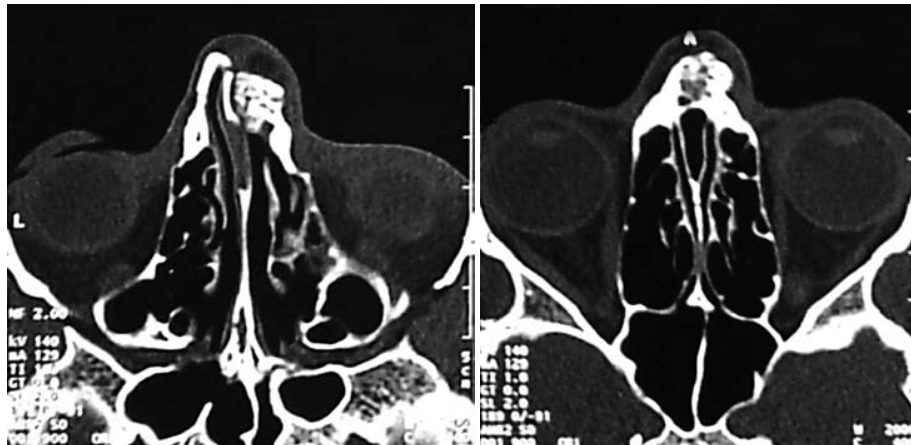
CT scans showing a 2x3-cm inhomogeneously enhancing soft tissue mass that destroyed the nasal bone.
